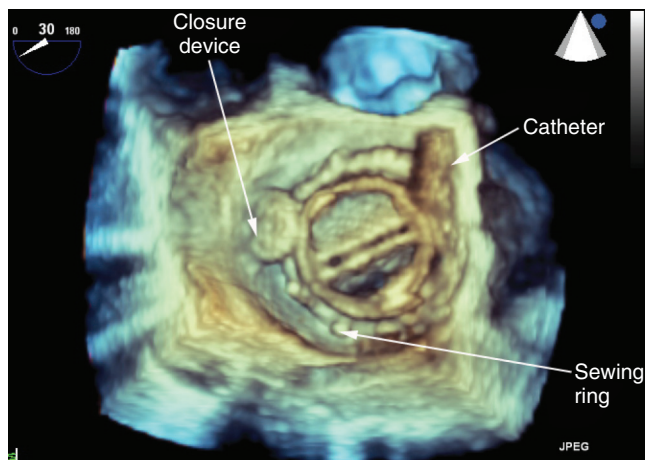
■ Three-dimensional transesophageal echocardiographic image of a mechanical mitral valve prosthesis. Two valve occluders are seen in the midportion of the image. There is a sewing ring around the valve. This patient developed valve dehiscence with paravalvular regurgitation. A small closure device was placed at the site of the defect along the sewing ring (arrow). A second closure device was being placed at the time of the study (catheter; arrow).
